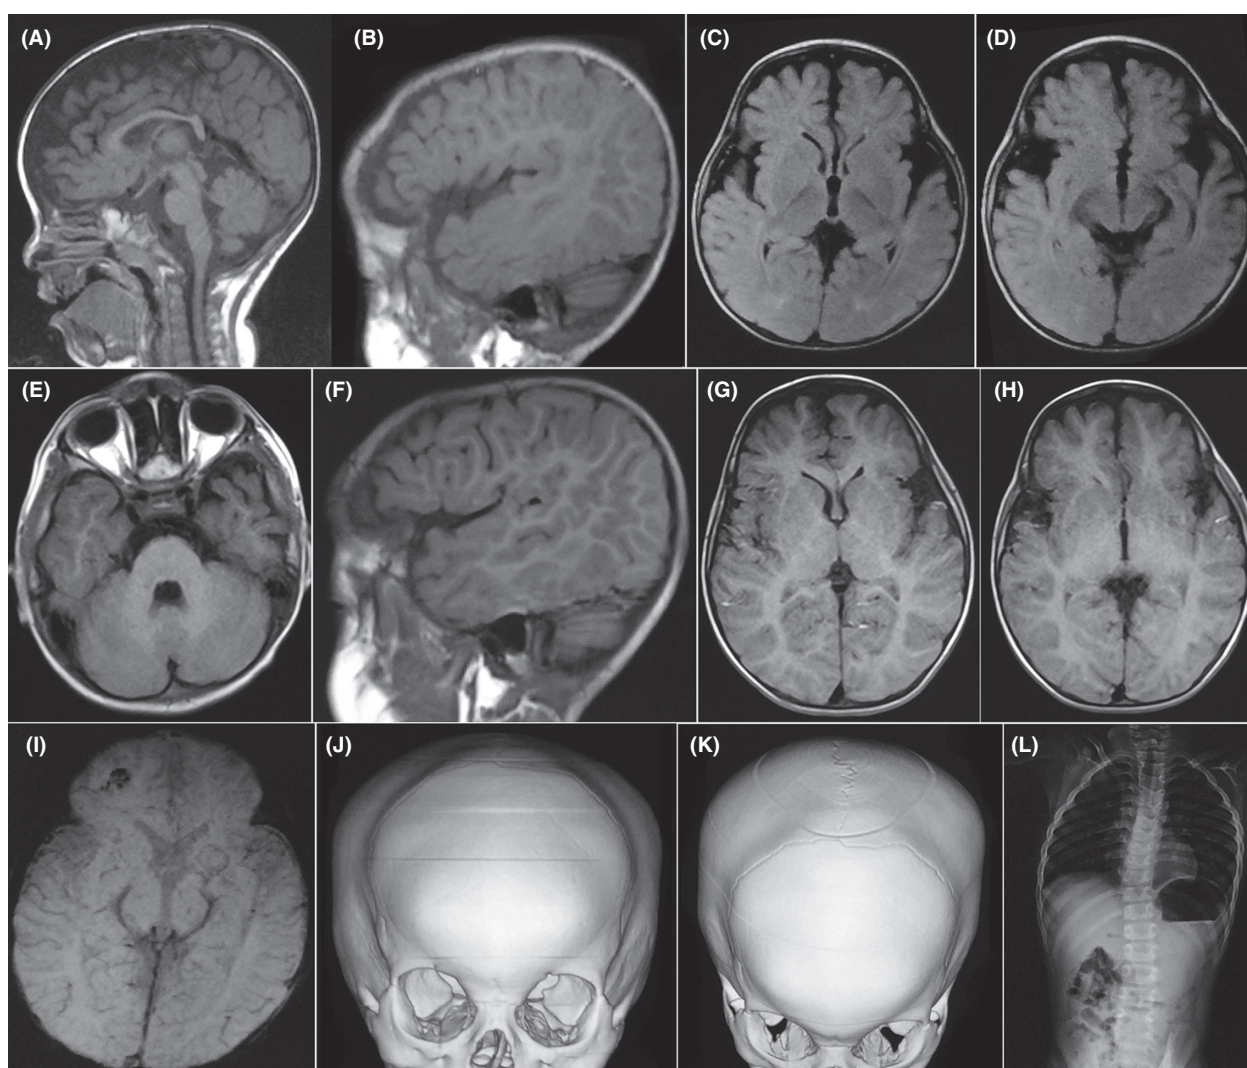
Imaging study taken at the age of 9 months (A–D, I), 2 years and 7 months (E–H), 3 years and 7 months (J, K), and 7 years and 5 months (L). T1 MRI imaging of the brain; sagittal plane: median (A), left side (B, F), and cross section (C–E, G, H). Cross-sectional SW1 MRI imaging (I). Frontal view of the brain by three-dimensional CT imaging (J, K) and of the spine by radiography (L). MRI, magnetic resonance imaging; CT, computerized tomography.
